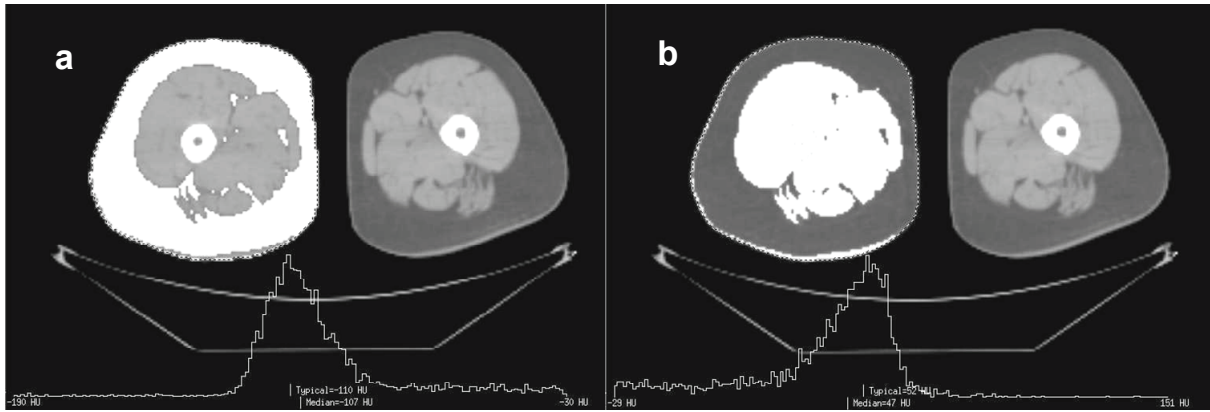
CT of the thigh (position 5 according to figure 7). Figure 2a shows the pixels categorized as adipose tissue (*i.e.* CT numbers from -190 to -30 HU) in white. The histogram representing these highlighted pixels is shown in the lower part of the image. Figure 2b shows the pixels categorized as muscle tissue (*i.e.* CT numbers from -29 to $+151$ HU) in white. The histogram representing these highlighted pixels is shown in the lower part of the image.
